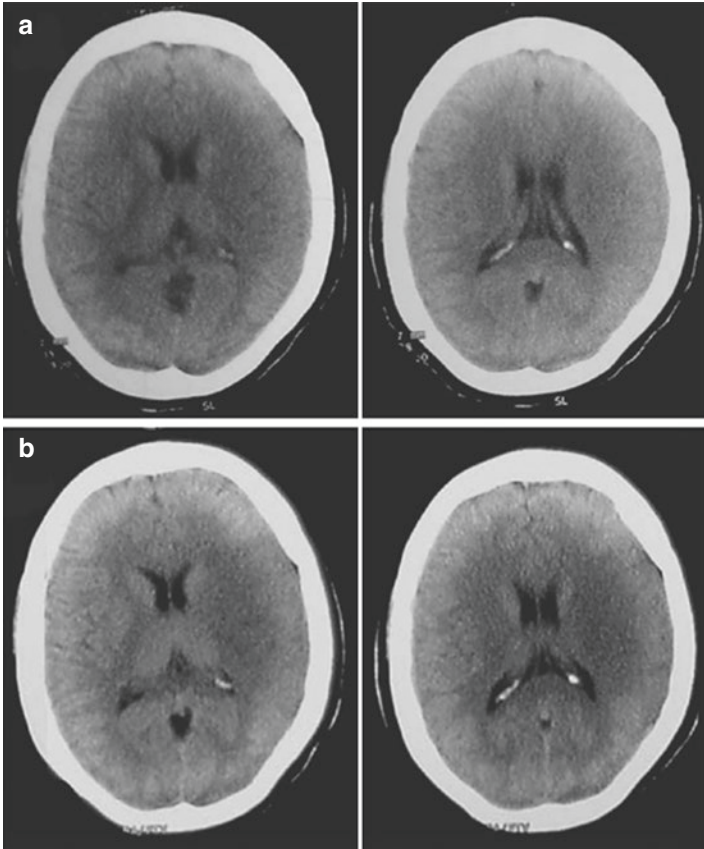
Non-contrast CT scans at 3 h (a) and 6 h (b) of a 40-year-old lady who presented with acute onset hemiplegia while cooking dinner in the kitchen. Can you tell which side has the low density? Don't forget the principles of comparing left and right focusing on the 'usual suspect' areas for infarction. Answer: Left side
